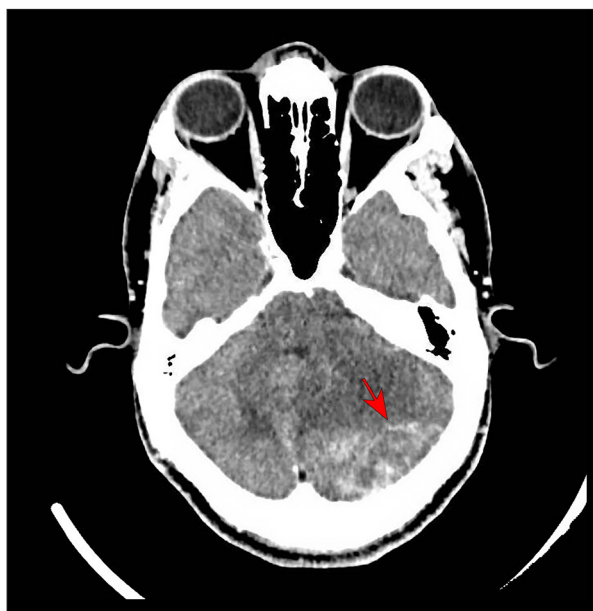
CT scan head (red arrow: ring-enhancing lesion (post-contrast images) seen in left the cerebellar folia measuring approximately 3.6×3.0 cm close to the left tentorium, with marked surrounding edema causing effacement of the fourth ventricle, pons, and part of the midbrain.
